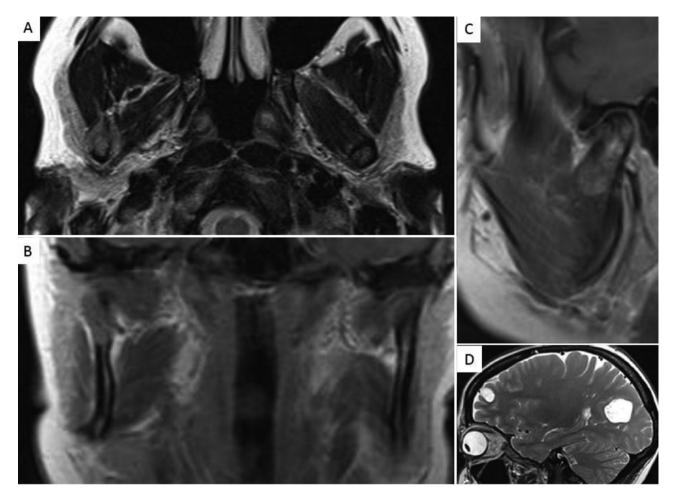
MRI shows the sharp boundary of the lesion against the soft tissues in axial (A), coronal (B), and sagittal projections (C). (D) Brain metastases that developed during treatment.
